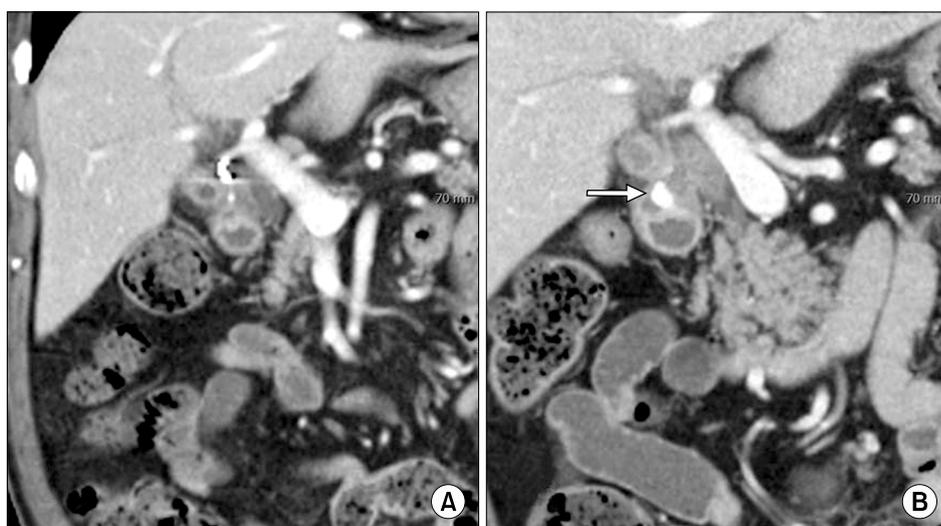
Follow-up computed tomography (CT) findings. Follow-up CT images show that the impacted stone (arrow) in the fistula tract has been disimpacted (A) compared with an initial CT scan (B).
